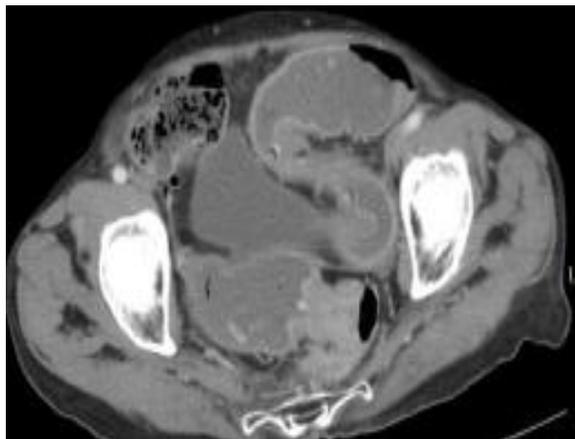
(a) CT- Carcinoma Recto-sigmoid causing intestinal obstruction
